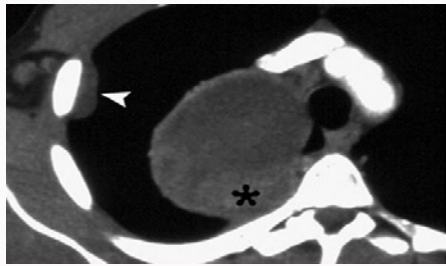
Synovial sarcoma in a 49 year-old female with dyspnea and pleuritic chest pain. Contrast-enhanced computed tomography scan demonstrates a predominantly cystic mass with an eccentrically thickened wall (asterisk) and peripheral rim enhancement. A metastatic nodule is seen (arrowhead) along the lateral pleural surface.
